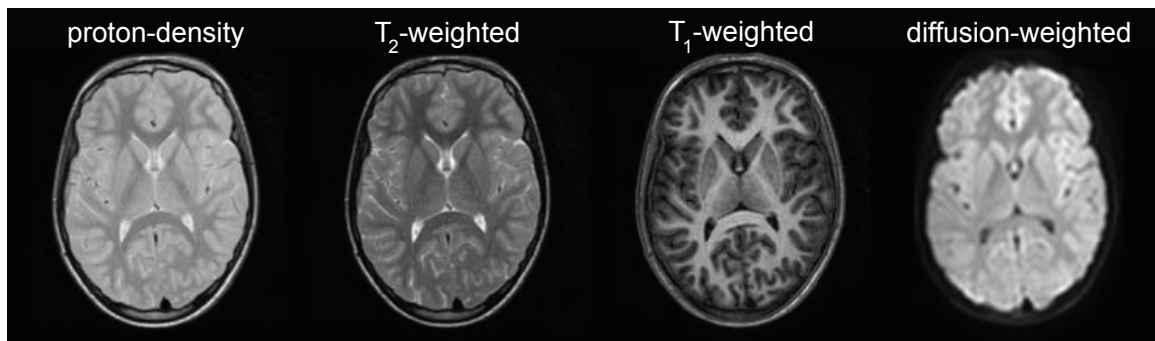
Various types of intensity weighting in MRI. Adapted from Mori [139].
